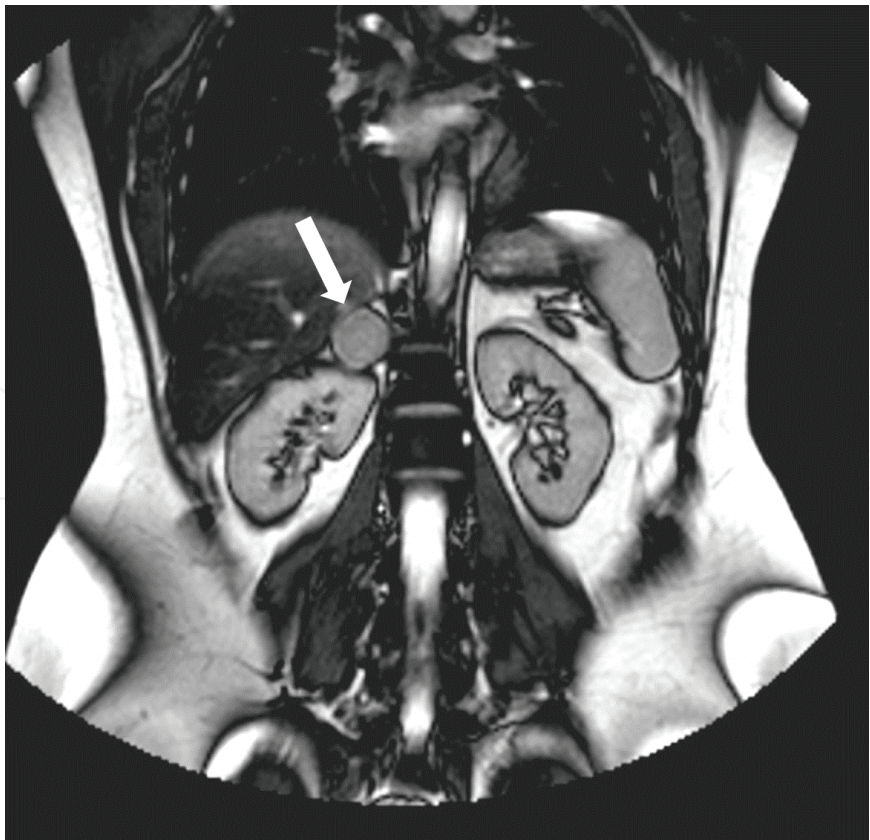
MRI: right adrenal adenoma (Cushing’s syndrome).
